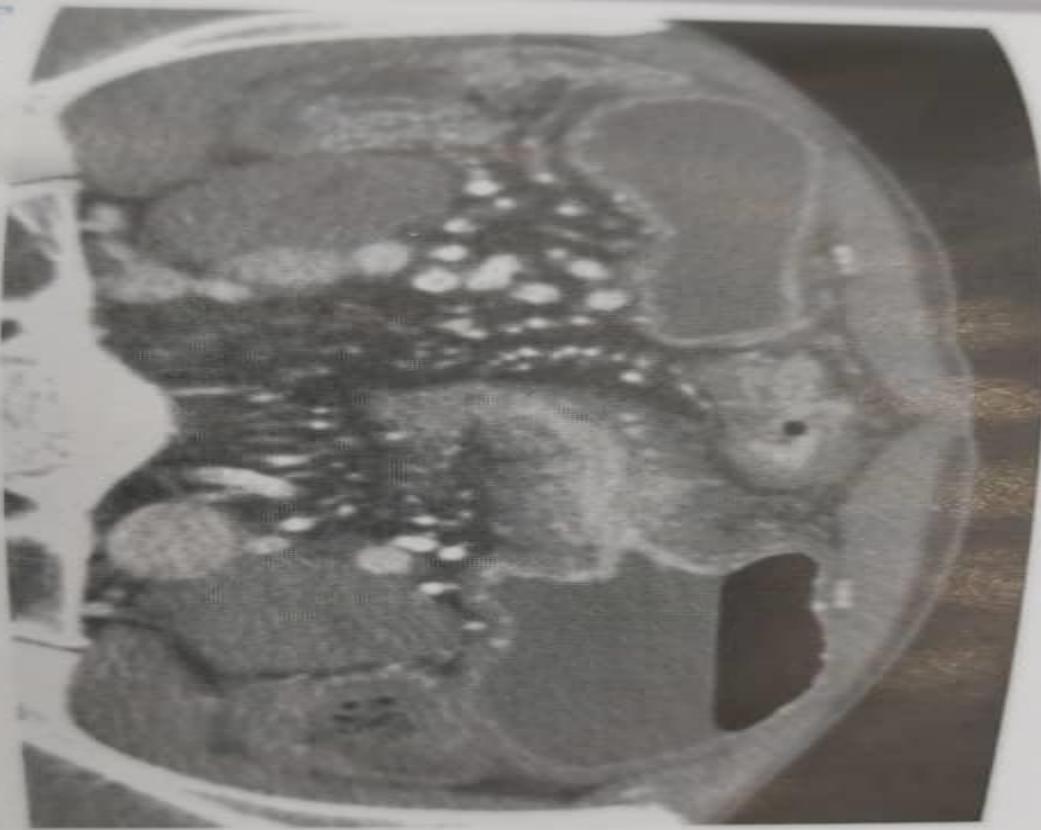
Computed tomography enterography in a patient with Crohn's disease. Note the multiple dilated bowel loops.
